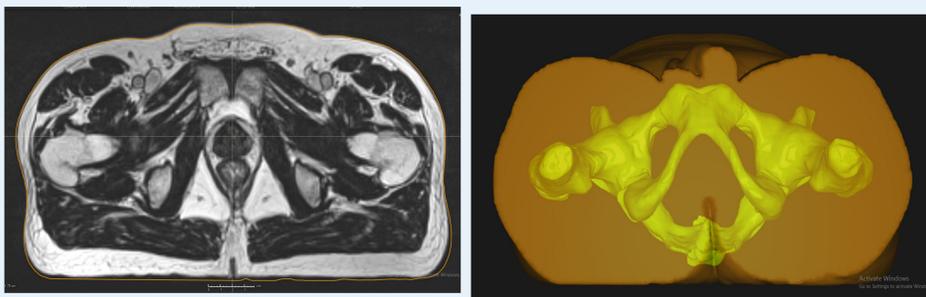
Left – MRI, Right – Segmented bone contour
